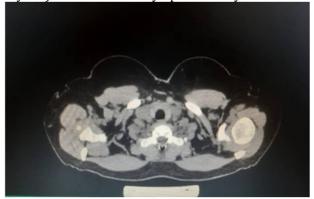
CT CHEST SHOWING MULTIPLE SUBCENTIMETRIC LYMPH NODES
